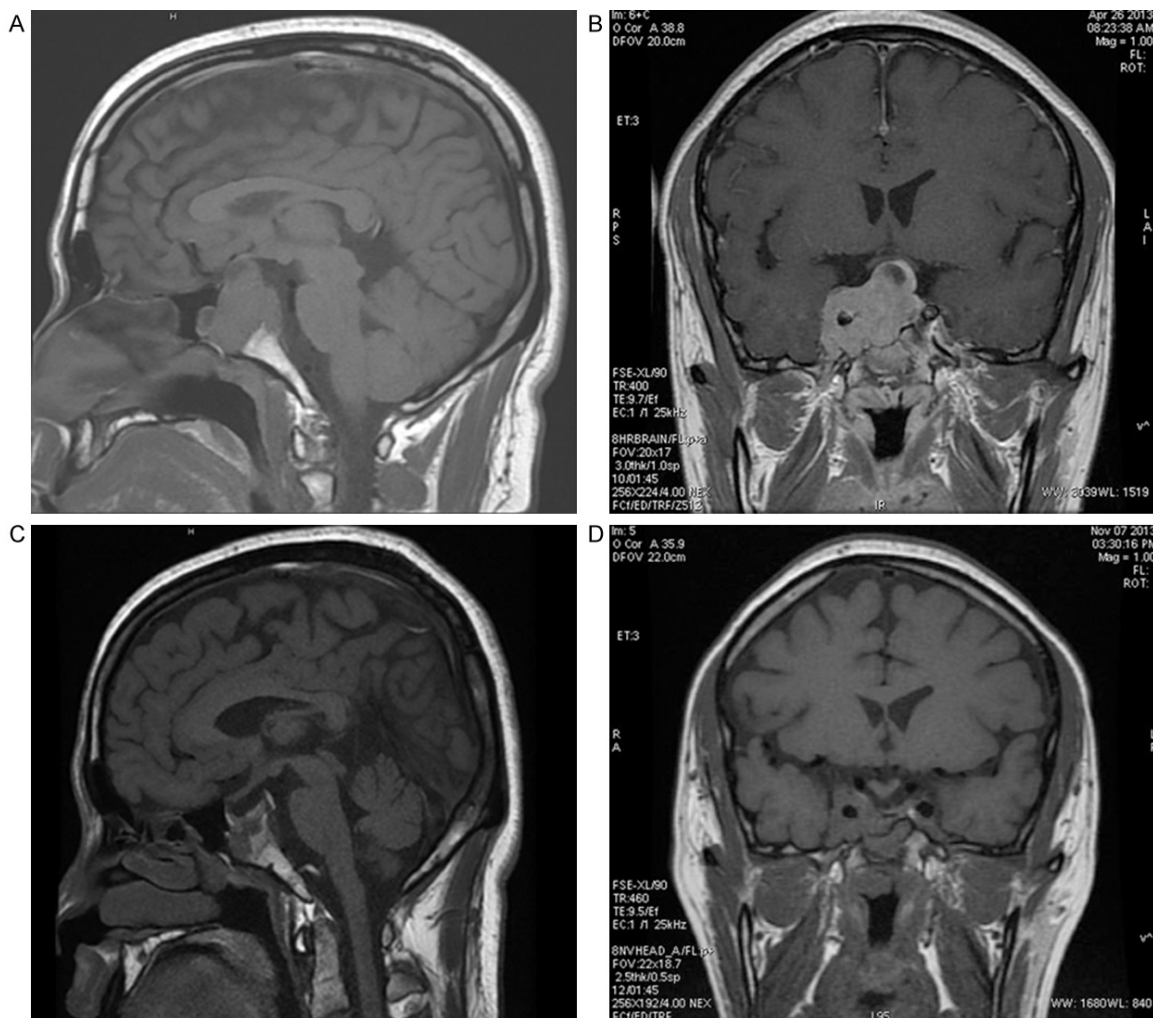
Magnetic resonance imaging scan of the brain before and after surgery. MRI scan of the brain showed the presence of a pituitary tumor with sellar and suprasellar extension that was wrapped around the left internal carotid artery. A, B. Sagittal and coronal T1-weighted MRI of brain scan on admission. C, D. Sagittal and coronal T1-weighted MRI of brain scan after surgery.
